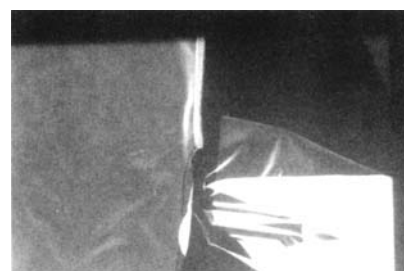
Radiograph of lead apron with detached lead in back of panel of apron. Left side is intact side panel, dark upper right area is absent of lead, light lower right area is multiple folds of lead.
